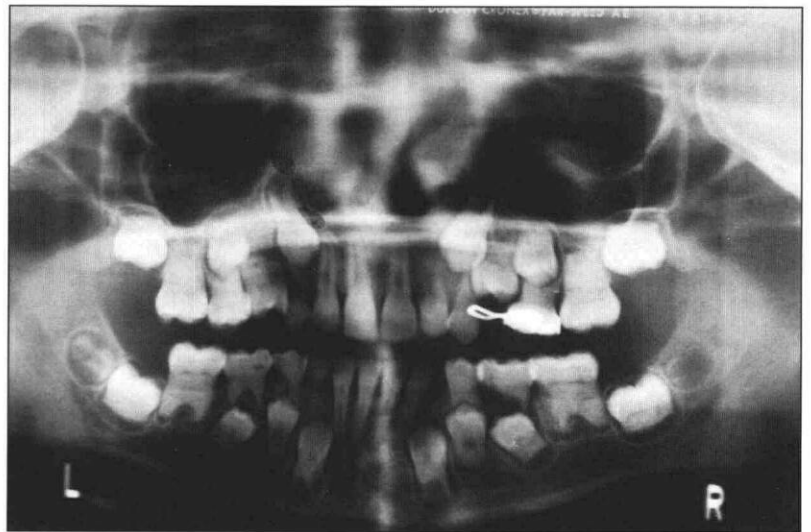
Panoramic radiograph of proband's brother. Note severe calcification and obliteration of the pulps of the posterior teeth, but relatively normal pulp chambers in the anterior teeth.
